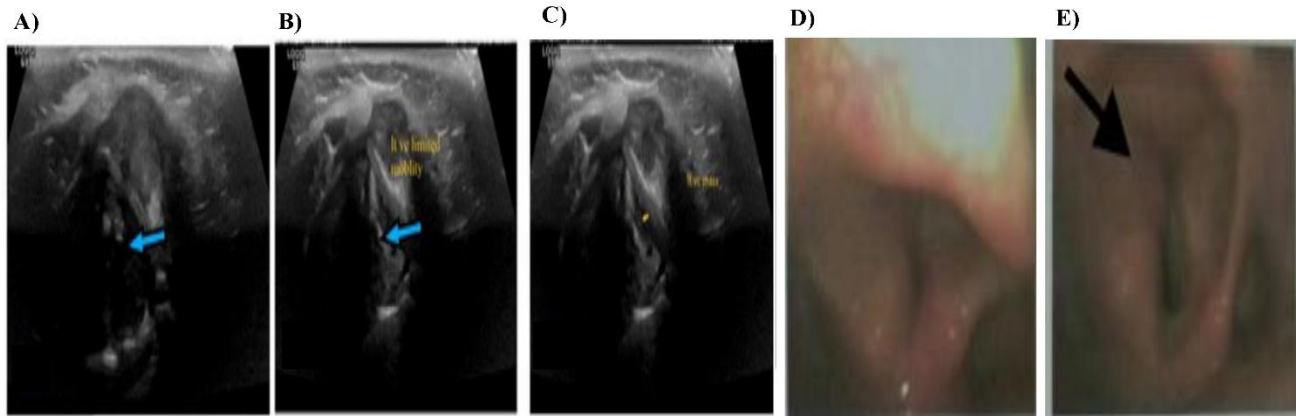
depicts the ultrasonographic findings of a female patient who was 71 years old, diabetic, and experiencing hoarseness of voice one month ago. Figure 8 also shows the ultrasonography findings of a male patient, forty years old, a smoker, and suffering from hoarseness of voice one year ago.
